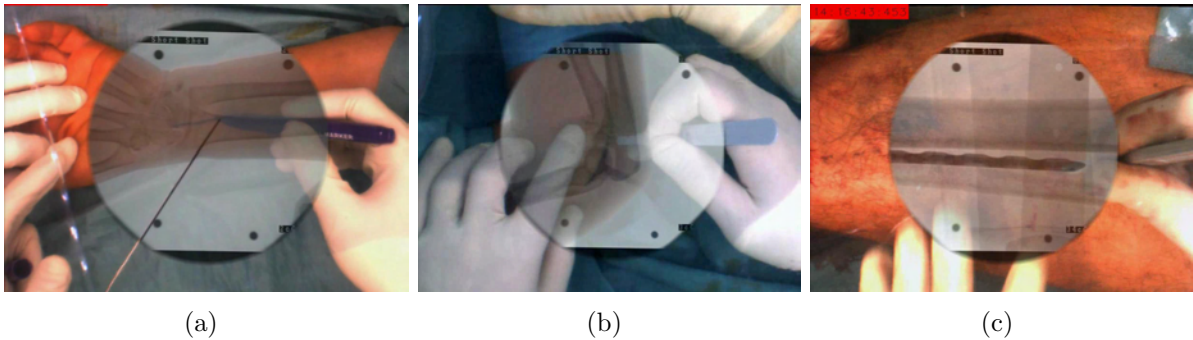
Incision path planning at a distal radius fracture (a), skin cut above a elbow fracture (b), and skin incision above the locking hole of the plate for its internal fixation (c), under the overlay of the X-ray and video images.
